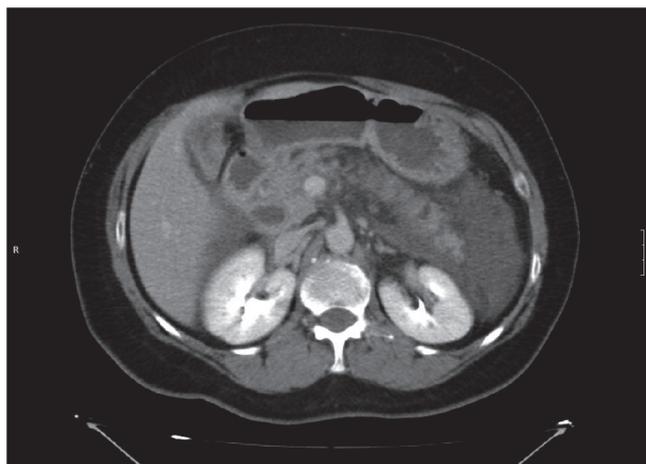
Abdominal CT scan shows the pancreas with signs of pancreatitis and retroperitoneal exudate and a residual cystic remnant in the head of pancreas. MRCP showing the residual cyst and its adhesion to the Wirsung duct. It also shows the jejunum anastomosed to the bile duct, laterally to the cyst.
